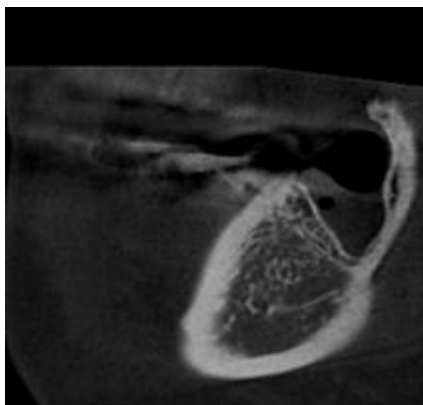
CBCT view. patient with mandible stage-2 MRONJ. There is empty dental socket, without demarcation line
